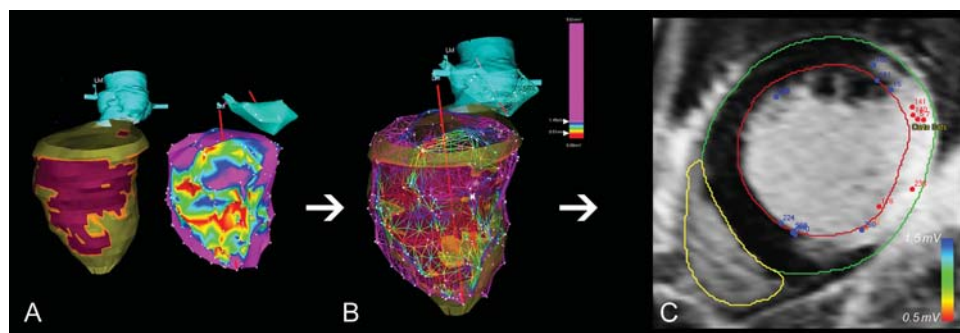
During the procedure, three-dimensional contrast-enhanced magnetic resonance imaging-derived meshes (purple represents scar and green represents normal myocardium) were integrated with the electroanatomical voltage maps (A and B) (colour coding as in the colour bar). After the procedure, colour-coded mapping points were superimposed on the contrast-enhanced magnetic resonance imaging slice at the corresponding location (C) (colour coding as in the colour bar).
